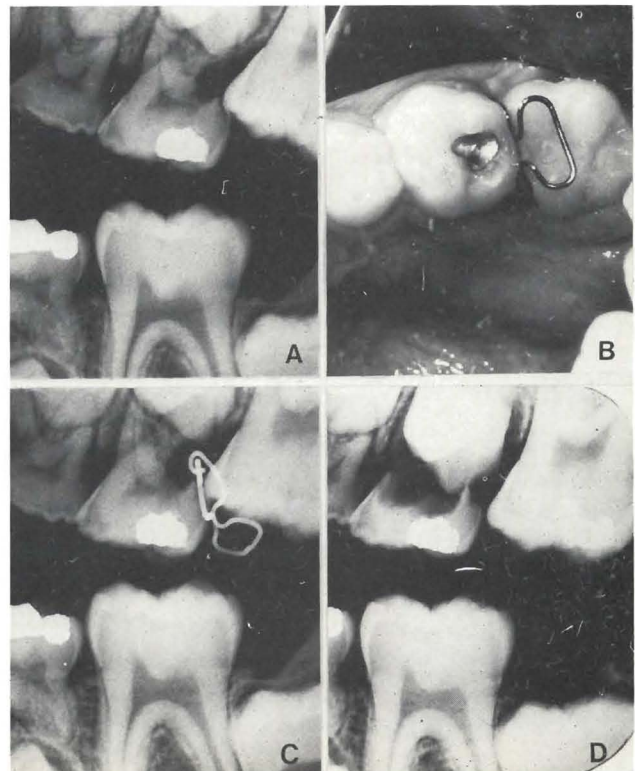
Treatment of ectopic eruption with a separating spring. A. Bitewing radiograph at the start of treatment, at seven years, three months of age. B. Occlusal view with the spring inserted. C. Bitewing radiograph with the spring at the start of treatment. D. Result of successful treatment at eight years, eleven months of age, when the primary molar is near exfoliation.*
